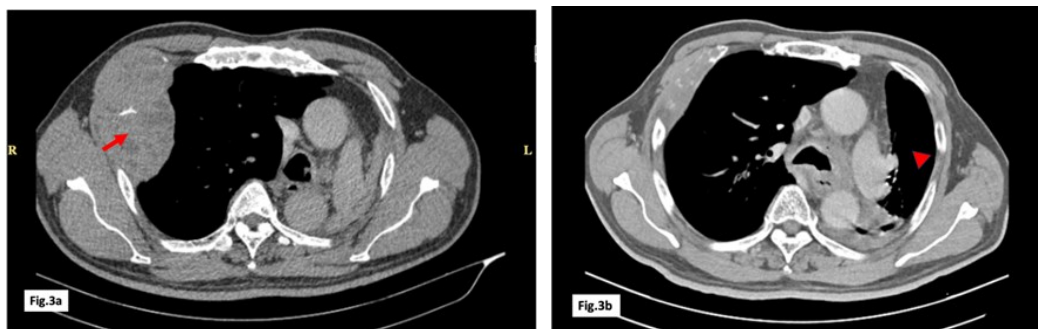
Chest CT scan with contrast (mediastinal view), pre- and post-treatment with thermal ablation and four cycles of intralesional cisplatin as adjunct to systemic chemotherapy. 3a: Pre-treatment scan shows a collapsed left lung with compensatory hyperaeration of the right lung, and a solid heterogeneously-enhancing pleural-based mass (arrow) in the right upper hemithorax associated osteolytic destruction of the 3rd lateral ribs. 3b: Post-treatment scan shows an interval partial re-expansion of the left lung (arrow head) with interval decrease in the size of the pleural-based mass with lytic expansile lesion along the right 3rd rib, 6.9 x 2.8 cm in maximal axial diameter (previously 10.6 x 6.4 cm). RMB: right mainstem bronchus; LMB: left mainstem bronchus
